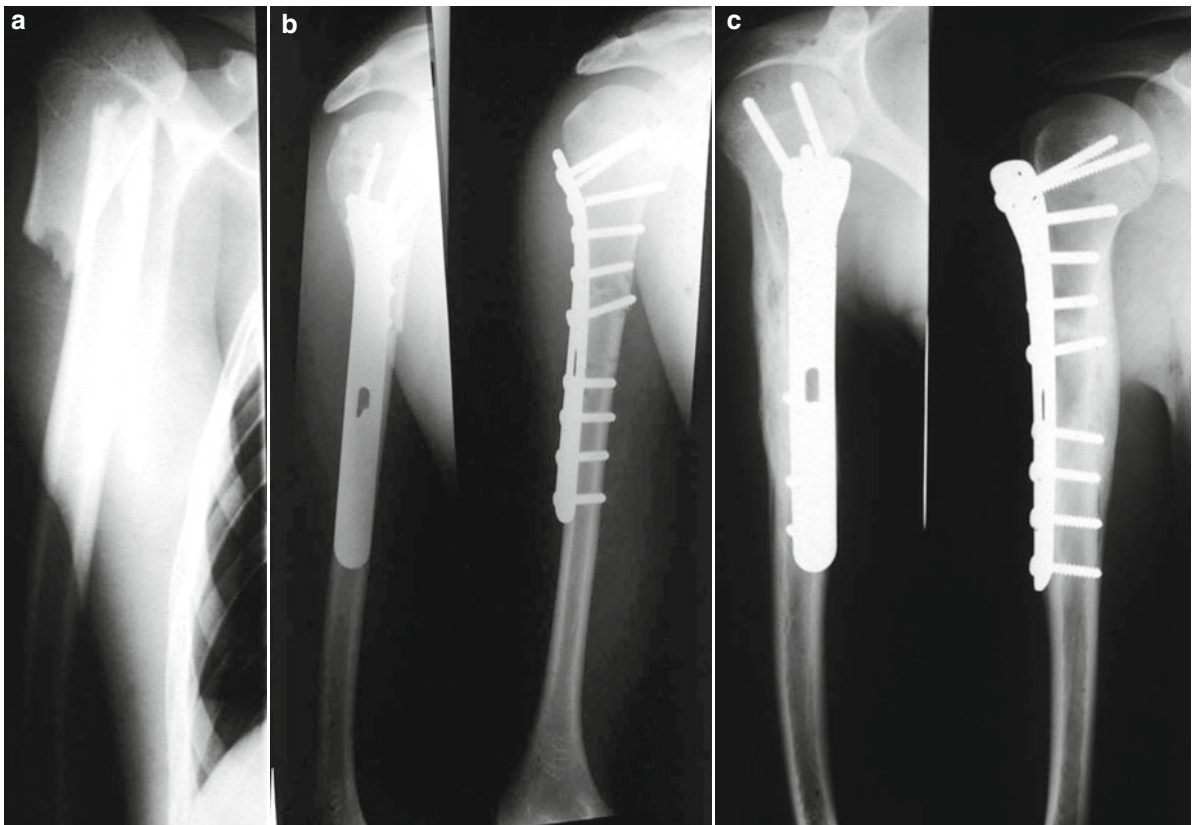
(a) Proximal transverse shaft fracture with important shortening in a 15-year-old boy after bicycle collision. (b) Anterolateral plating. Postoperative AP and lateral views. (c) Control X-rays after 6 months. Free shoulder and elbow function
